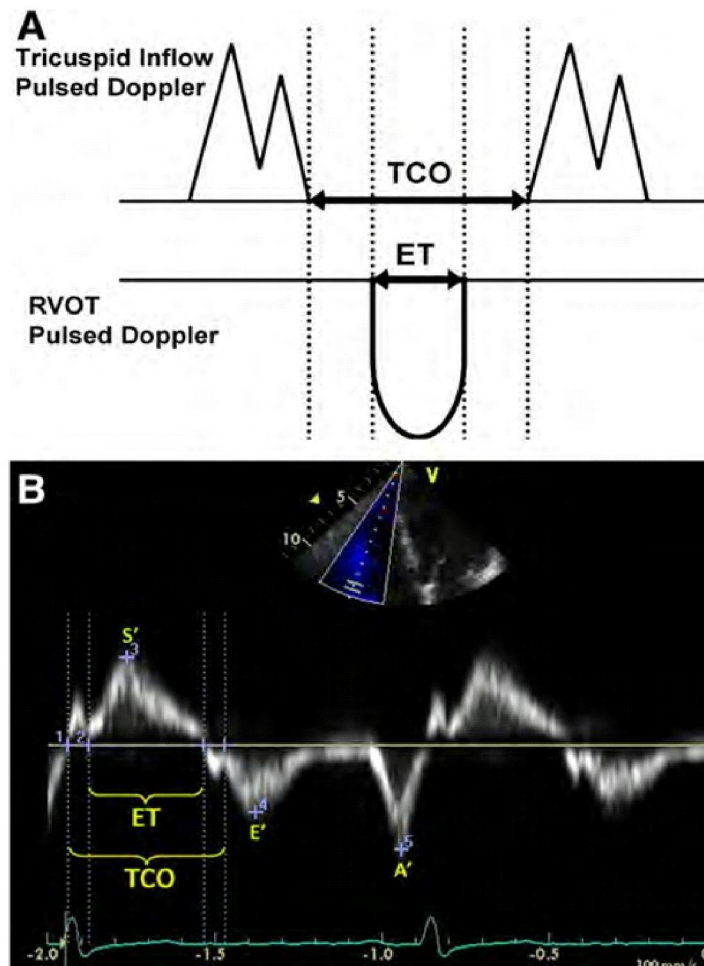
Calculation of right ventricular myocardial performance index (MPI) by pulsed Doppler (A), and pulsed tissue Doppler (B). The tricuspid valve closure opening time (TCO) encompasses isovolumic contraction time, ejection time and isovolumic relaxation time. In the pulsed Doppler method TCO can also be measured by the duration of tricuspid regurgitation continuous wave Doppler signal ($MPI = TCO - ET / ET$). Note that S' , E' and A' are also measured from the same pulsed Doppler tissue image.
